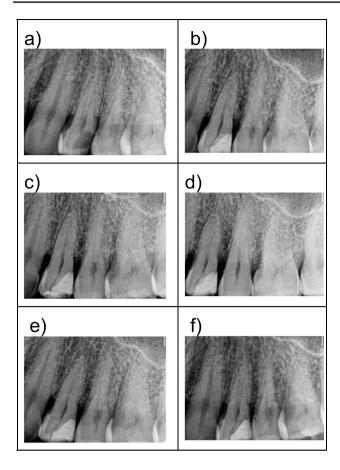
a–f Radiography of the tooth (#24) with preop severe sensitivity, dark brown slowly progressing carious tissue characteristics and pulp exposure during SRSD a preop b immediately after treatment c 3 months, d 6 months, e 1 year, and f 2 years follow-up with vital pulp, dentin bridge formation and without apical radiolucency
